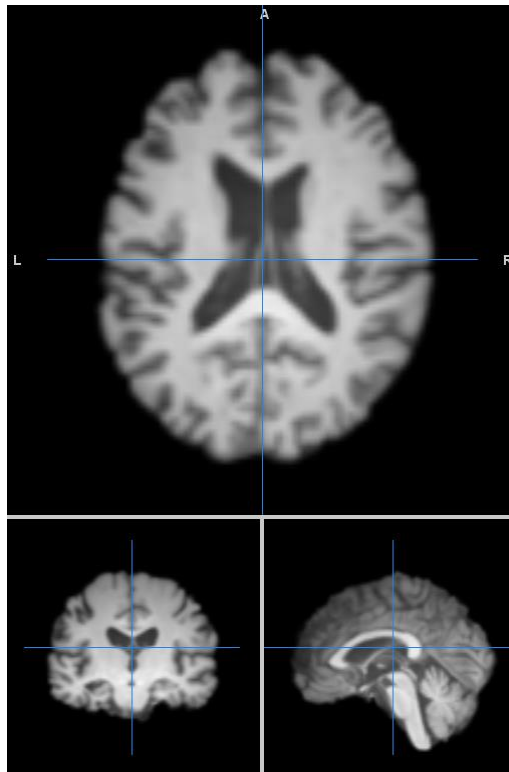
Skull-removed structural MRI image of AD subject 006_S_4153 in MNI space
